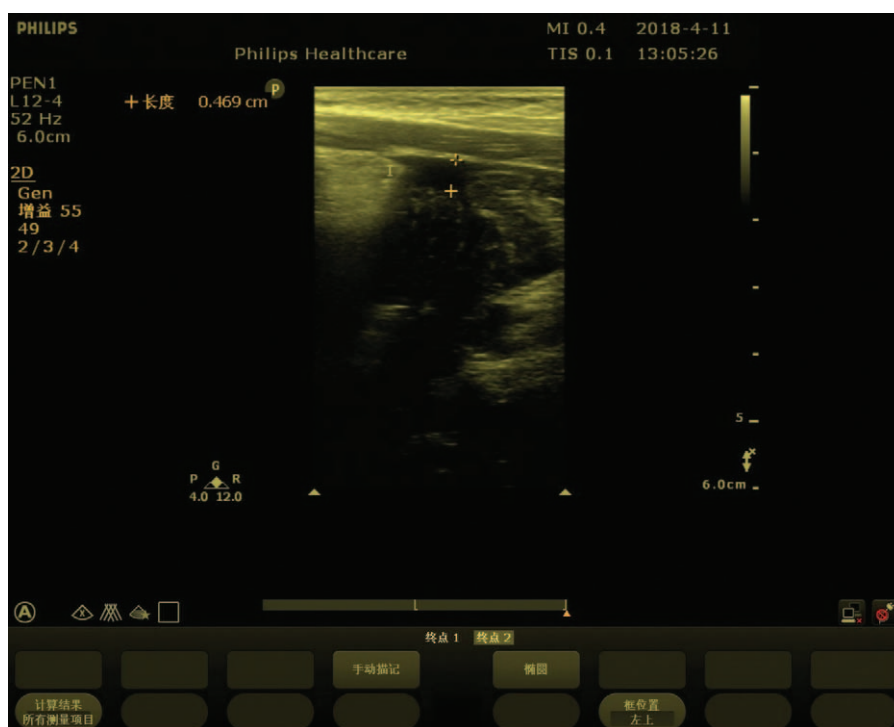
Abdominal ultrasound on the 12h of admission, demonstrating a 0.94 cm deep right iliac fossa.
